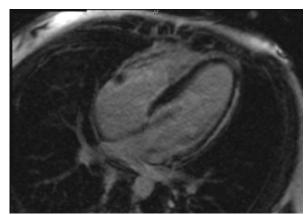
Cardia MRI showing sub-epicardial late gadolinium enhancement involving apical and mid and basal Infero-lateral segments
